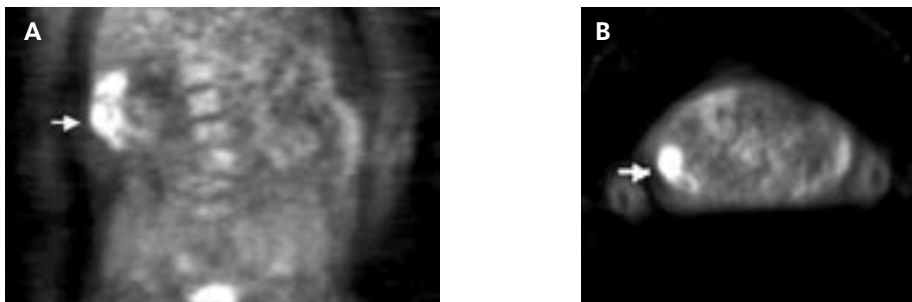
Patient A with a history of ADPKD and renal transplantation presented with fever. Coronal (Figure 1A) and transverse (Figure 1B) projection of PET 2: the arrow indicates the large and irregular FDG-uptake dorsally in the right kidney extending to the right liver lobe, suggesting infection.
